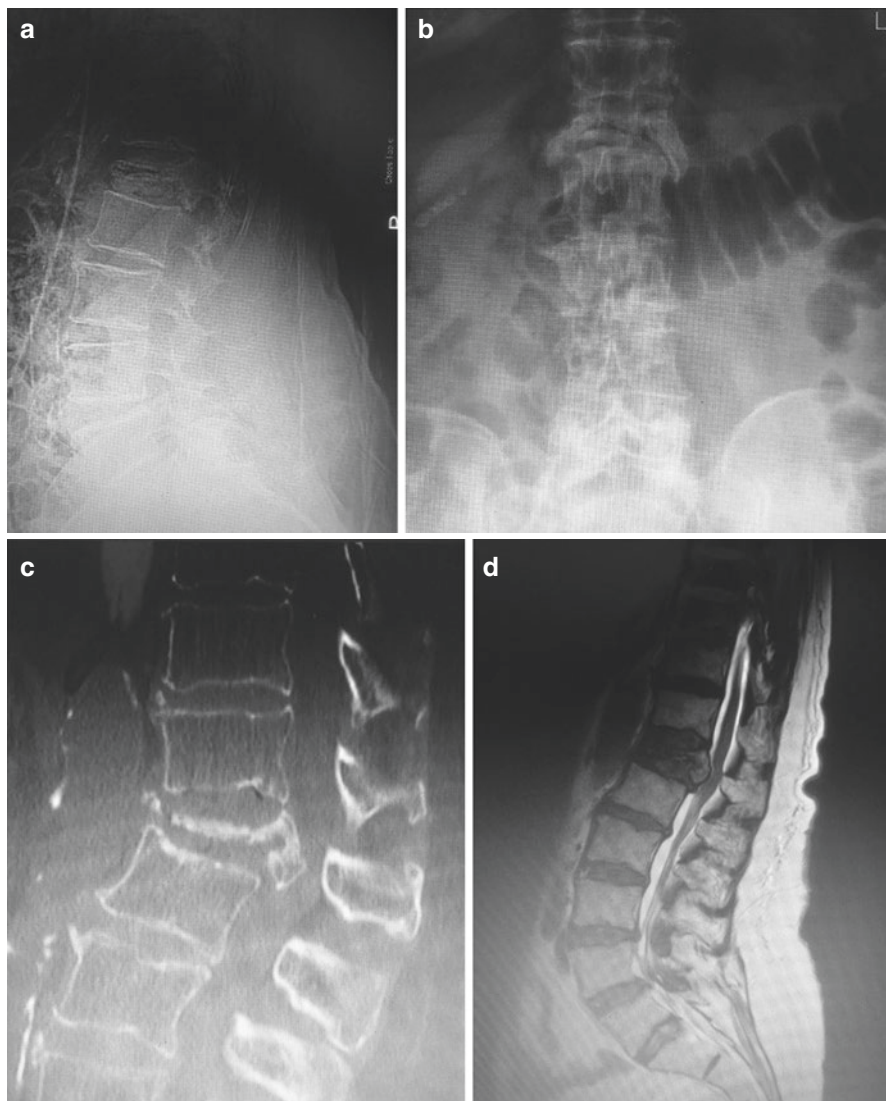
(a, b) A 78-year-old with osteoporotic fracture of T12. The appearances result in vertebra plana which may mimic TB of the vertebral body. (c, d) CT scan and T2 weighted sagittal MRI scan image of the patient with osteoporotic fracture. The discs are preserved which rules out discitis. CT scan reveals the bone loss and vertebra plana
